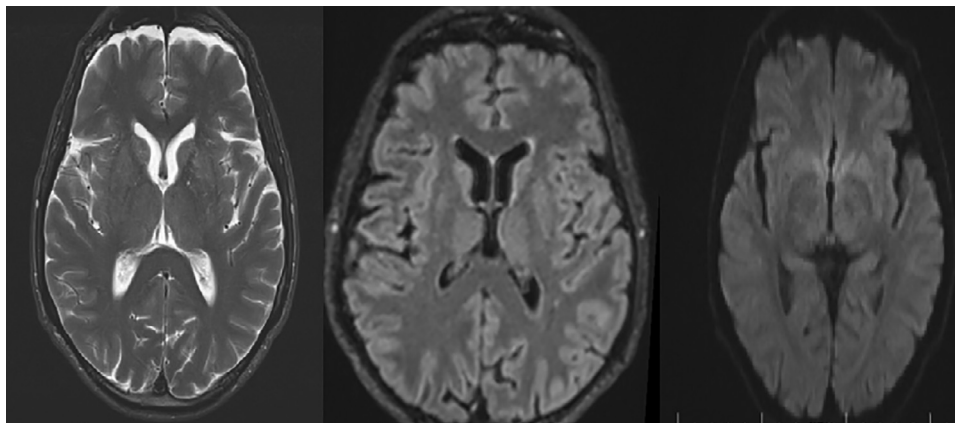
Brain MRI: Axial sections on T2-weighted, FLAIR, and Diffusion sequences.
